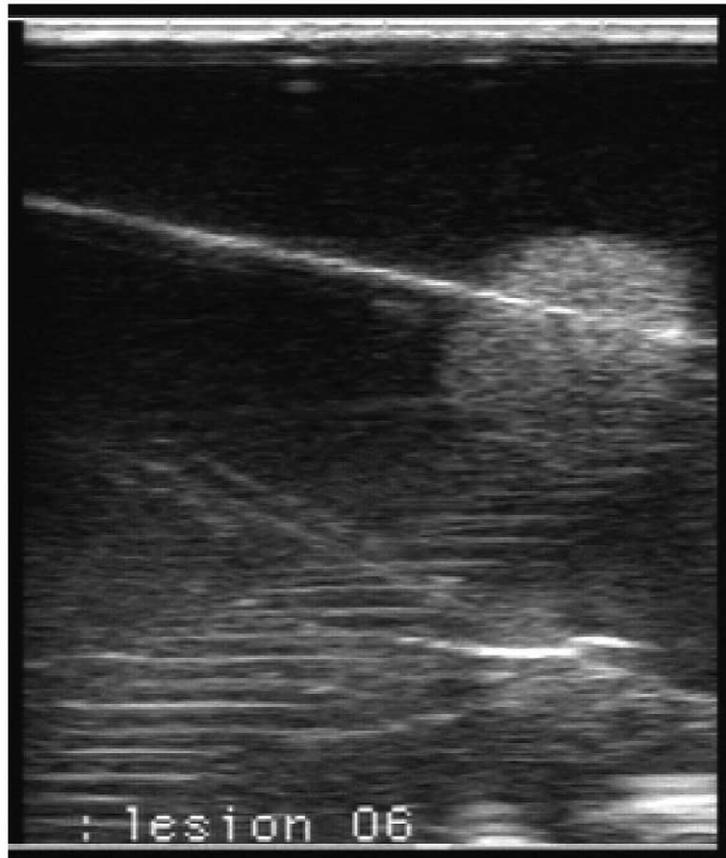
Lab view (top) and ultrasound image (bottom) while the physician, wearing the Glasstron-based head-mounted display (HMD), performs a controlled study with the 2000 system. She holds the opto-electronically tracked ultrasound probe and biopsy needle in her left and right hands, respectively. Refer to Fig. 3 for an example of the view from the HMD. The horizontal streaks in the ultrasound image are common artifacts of acoustic reflection. A colour version of this figure is available at www.elsevier.com/locate/media (go to Electronic Annexes).
